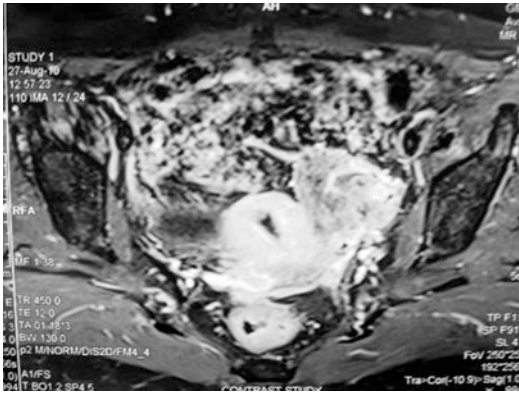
MRI study showing the left adnexal mass (On HPE: Fallopian Tube Carcinoma)
